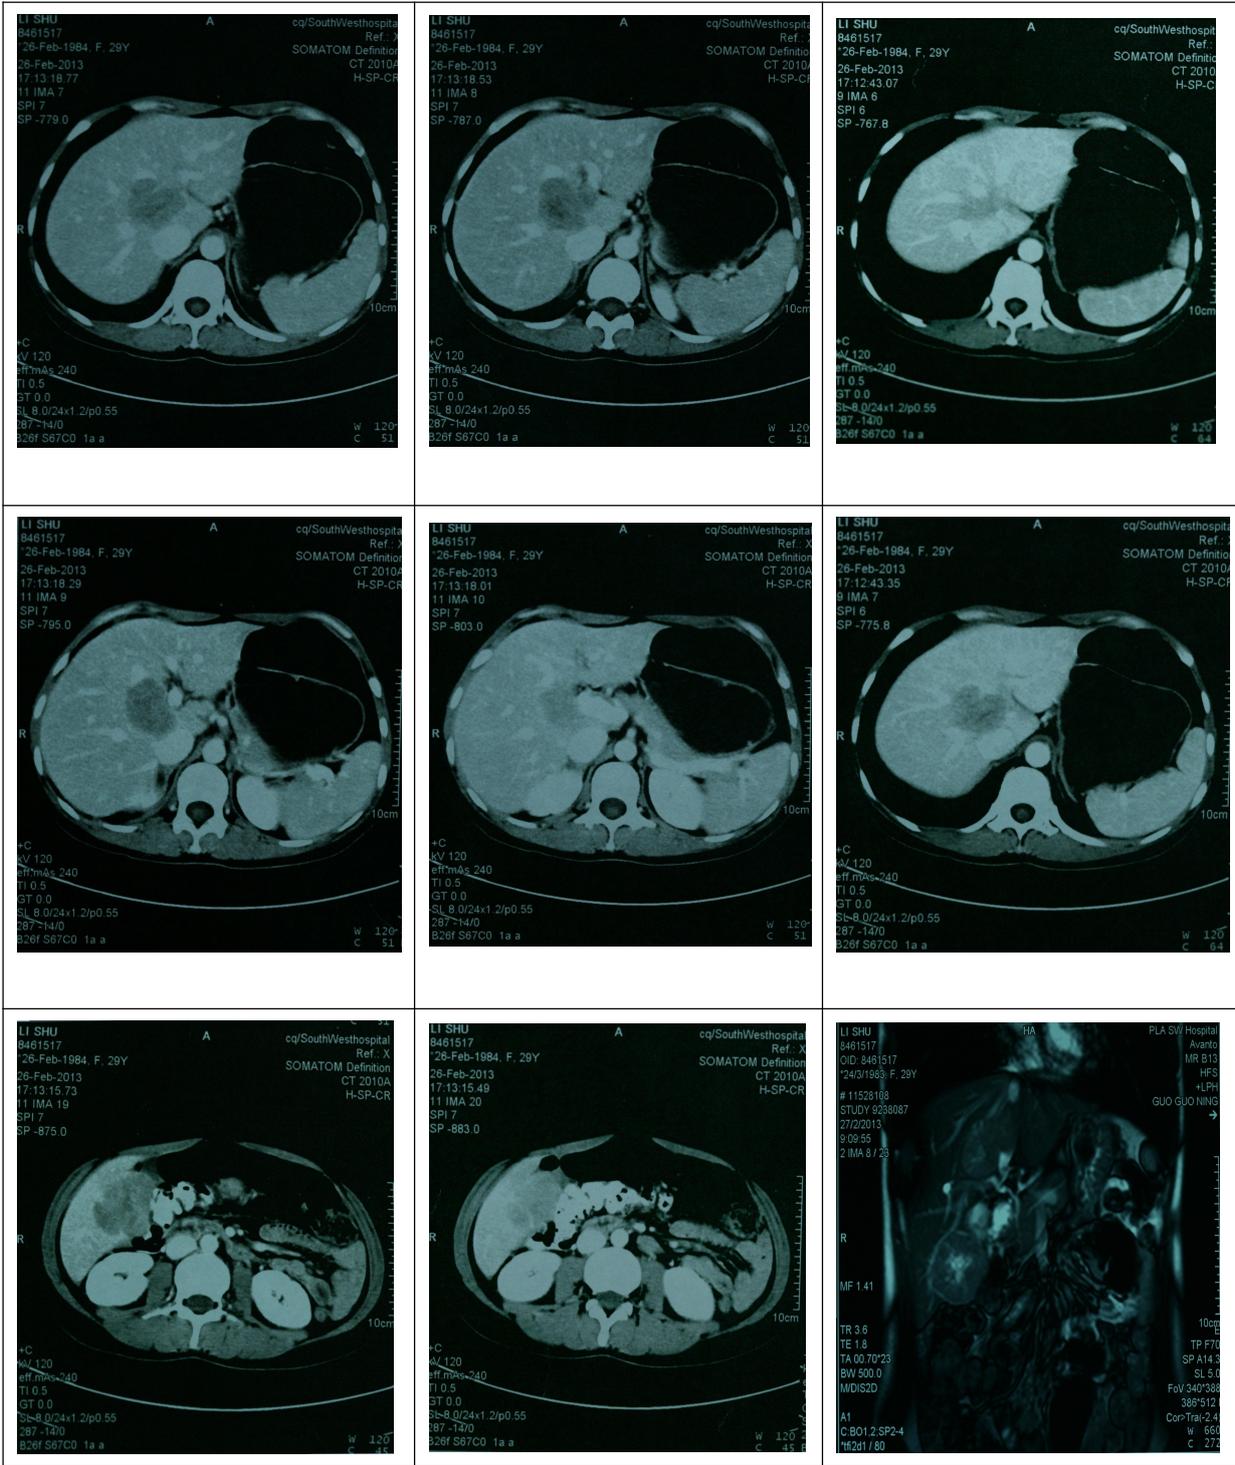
Selected Preoperative Abdominal CT Image
